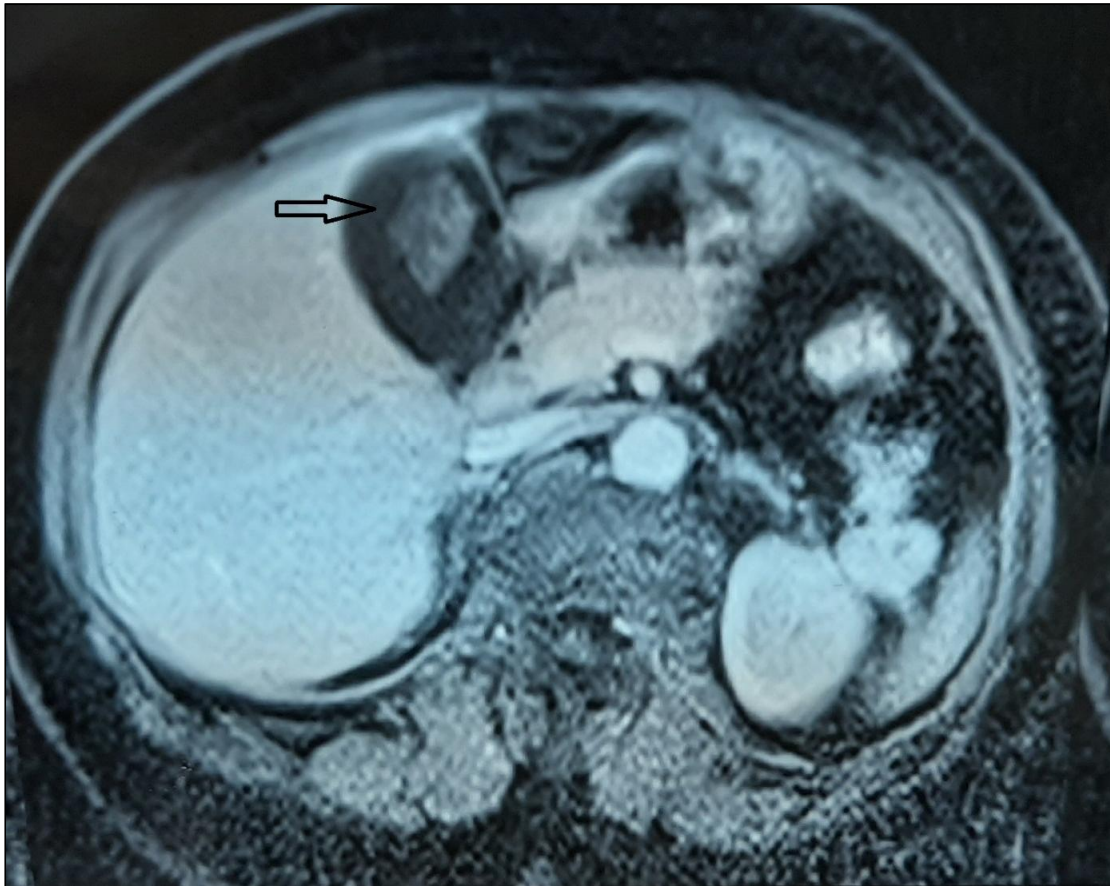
Biliary magnetic resonance imaging (MRI) in axial section: budding lesion process at the fundus of the gallbladder
